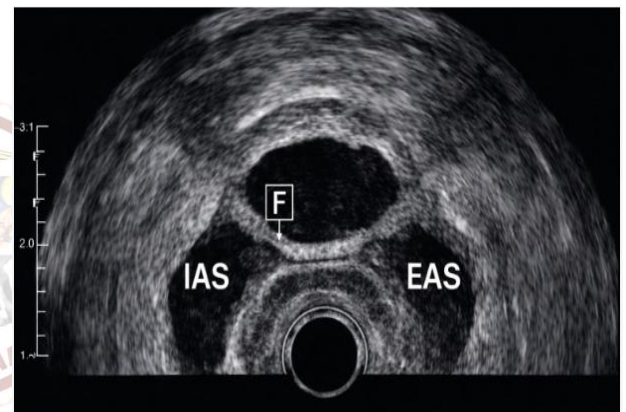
Endoanal ultrasound (axial view) demonstrating a fistulous tract (marked "F") in the intersphincteric plane, indicating involvement of the sphincter complex
